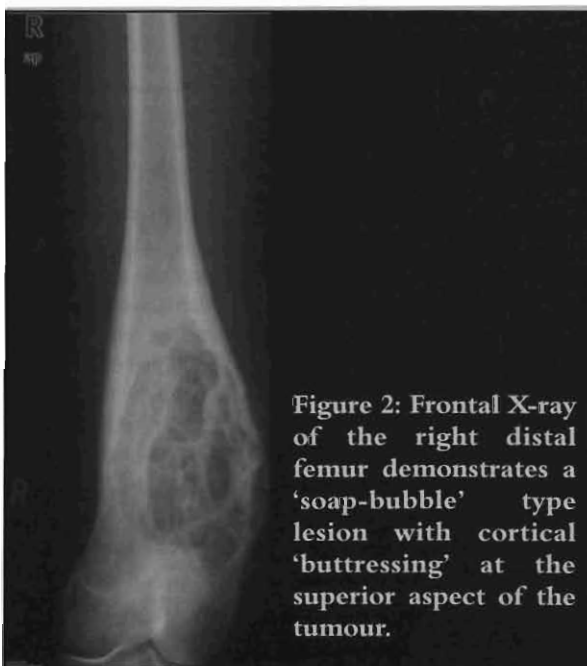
Frontal X-ray of the right distal femur demonstrates a 'soap-bubble' type lesion with cortical 'buttressing' at the superior aspect of the tumour.
